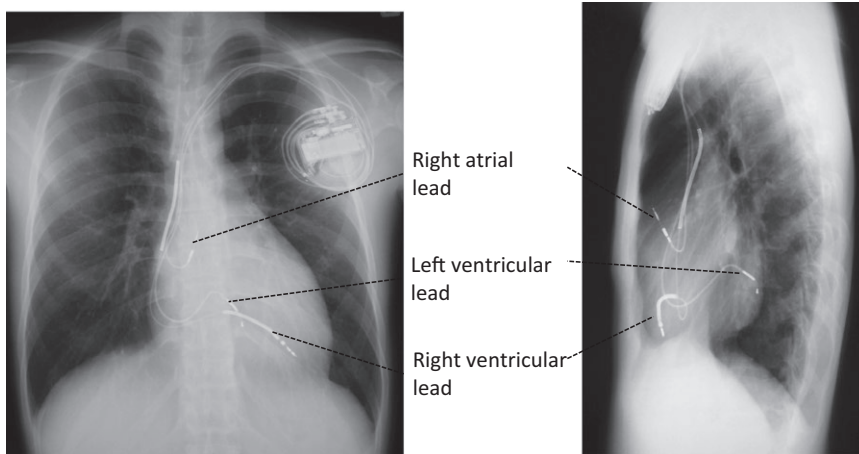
Chest x-ray after implantation of defibrillator with cardiac resynchronization therapy (CRT-D). Three leads are placed in the heart transvenously. Left ventricular lead is placed in the coronary sinus branch
